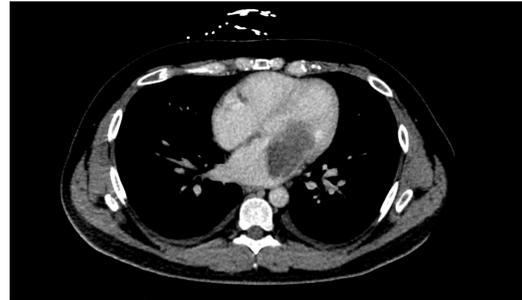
CT Imaging demonstrating filling defect
